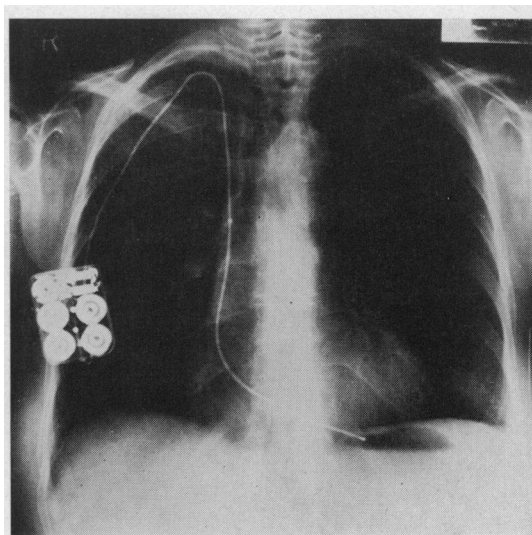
Chest radiograph showing the endocardial-jugular system with buried pacemaker.
